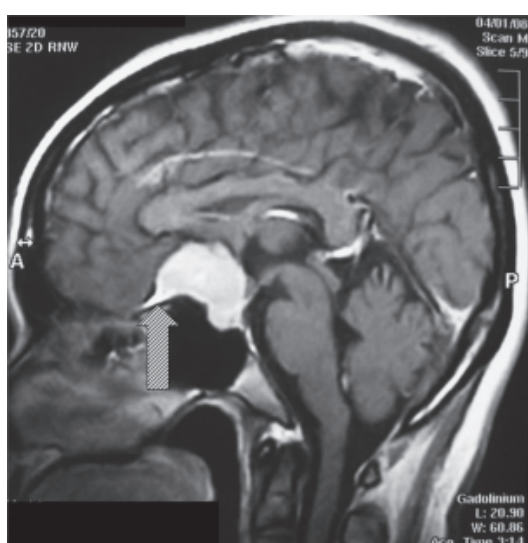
MRI brain with intravenous gadolinium enhancement showed a nodular tumour with a tail of meningeal enhancement (arrow) extended onto the cribriform plate.
